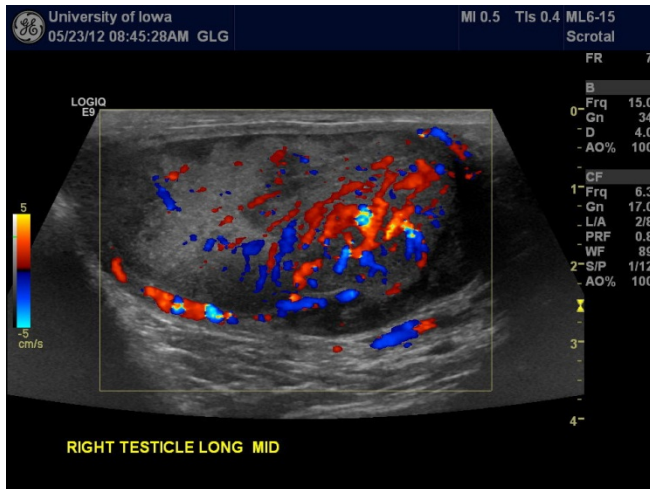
Color Doppler exam of the right testis shows hypervascularity especially in the hypochoic regions, which is highly suspicious for malignancy, but infection is not excluded.
